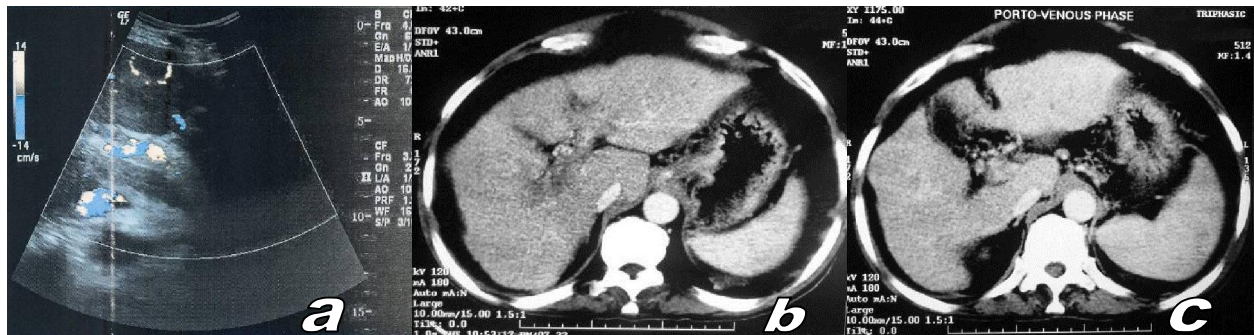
male patient 50 years old, liver cirrhosis (a) color Doppler examination showing patent main PV and left PV branch showing normal color flow pattern yet the right PV branch shows no color flow denoting its thrombosis. (b) Axial CT portography at extrahepatic level showing patent contrast enhanced opacified main portal vein with no evidence of thrombosis. (c) Axial CT portography at intrahepatic level showing patent contrast enhanced opacified left portal vein yet the right portal branch was not opacified and showed no contrast enhancement denoting its thrombosis.
